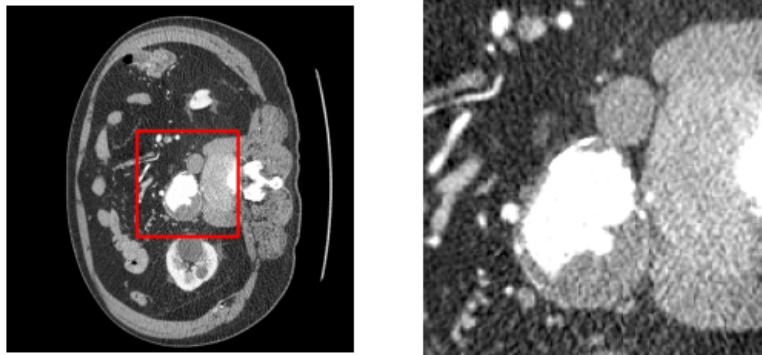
(Re-scaled) CTA and (Re-scaled) cropped CTA. (Patient 1)
